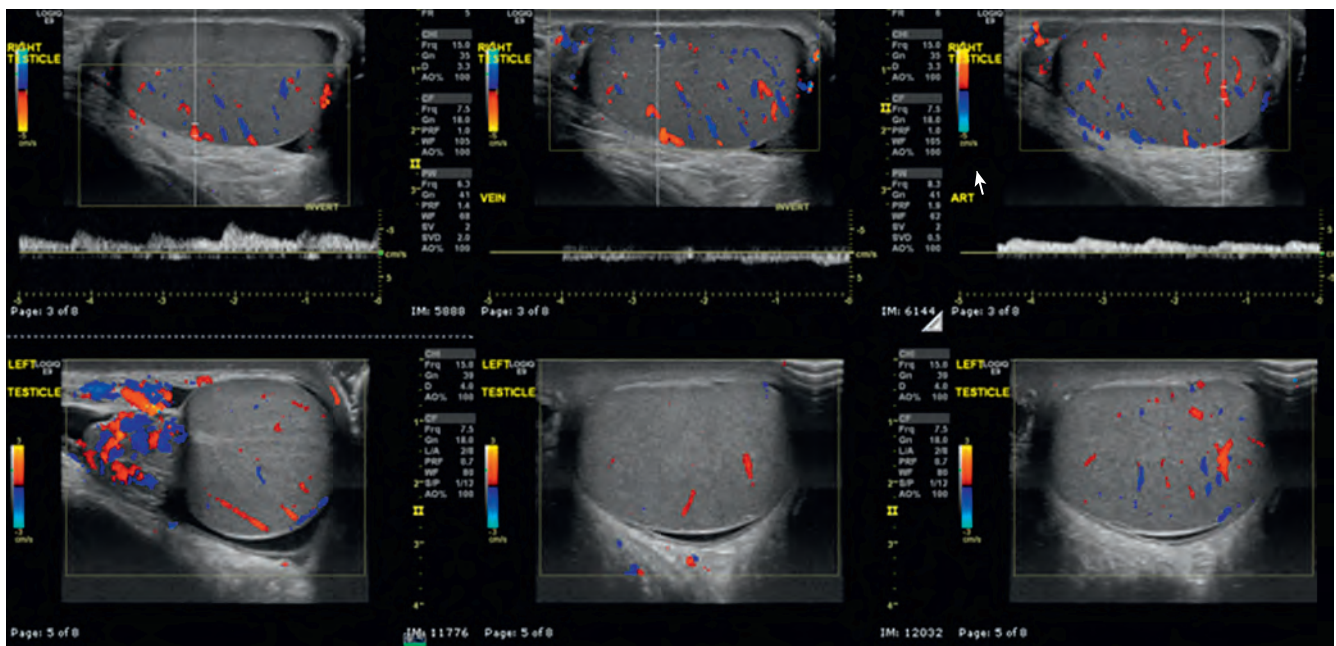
Scrotal sonogram in a 13-year-old boy with acute onset of left scrotal swelling showing hyperemia of the left epididymis consistent with epididymo-orchitis.
